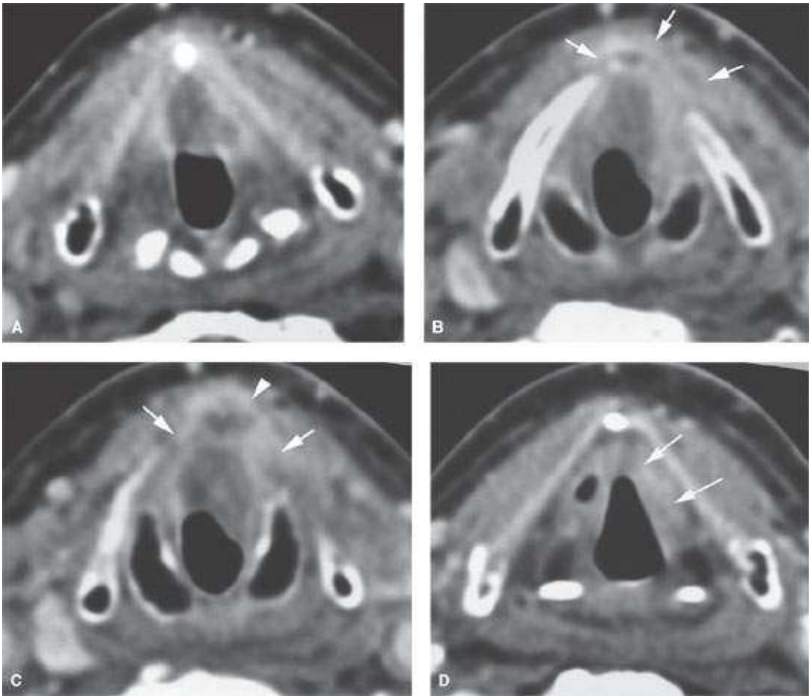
Contrast-enhanced computed tomography study of a cancer at the anterior commissure. The tumor was originally treated with radiotherapy for cure. Its extent may have been originally underestimated. The patient presented to us with recurrent hoarseness and pain for further evaluation and treatment. On physical examination, there was no definite mucosal disease. A: A bulky mass is present at the anterior commissure. B: Just below the anterior commissure, the mass appears to erode through the undersurface of the thyroid cartilage into prelaryngeal soft tissues (arrows). C: There is continued subglottic spread and spread into the prelaryngeal soft tissues (arrows). D: Cephalad spread to the paraglottic space at the level of the false cord was also present (arrows).
